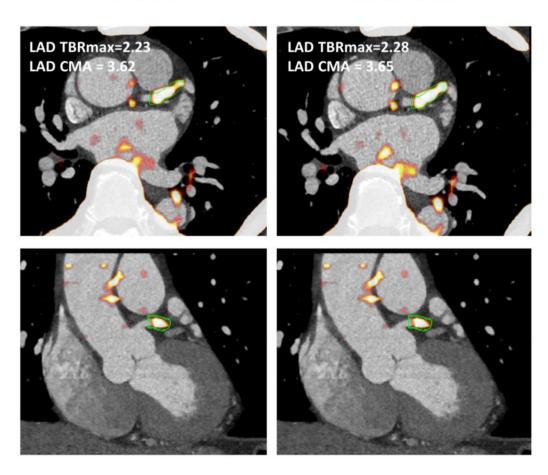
Left anterior descending artery ¹⁸F-NaF uptake. Left panel shows fused CTA and PET images reconstructed using the CTAC maps, whereas right shows the same CTA fused with PET an image reconstructed using RACTAC. There is good agreement between the measurements.
